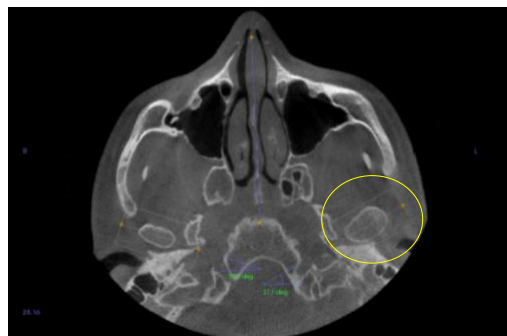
Axial CBCT cross-section demonstrating a hyperplastic left condylar head
